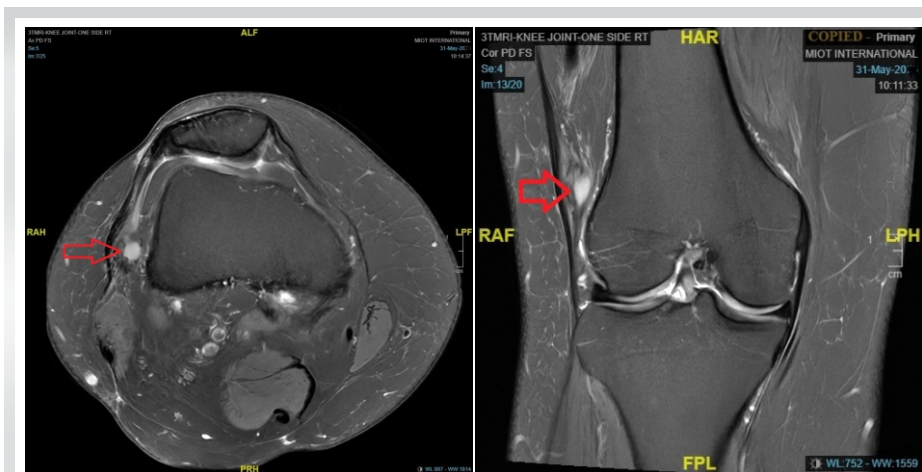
Magnetic resonance imaging scan of the right knee joint in 2023 shows that there is a cystic lesion in close proximity to the lateral femoral condyle in coronal and axial sections.
